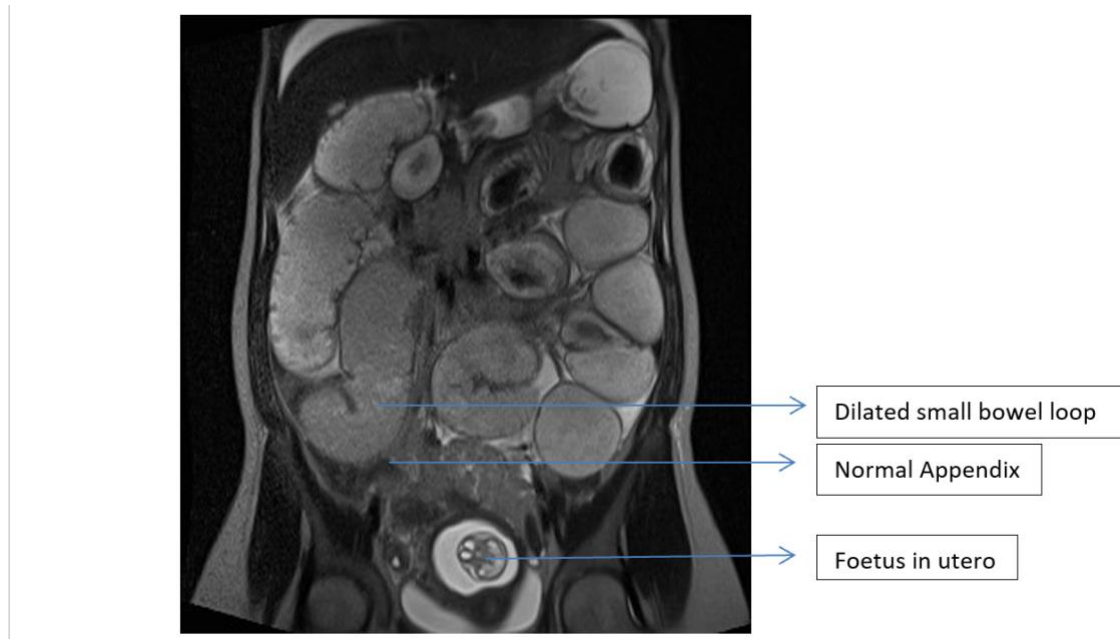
Coronal section of Magnetic resonance imaging of the abdomen and pelvis.
